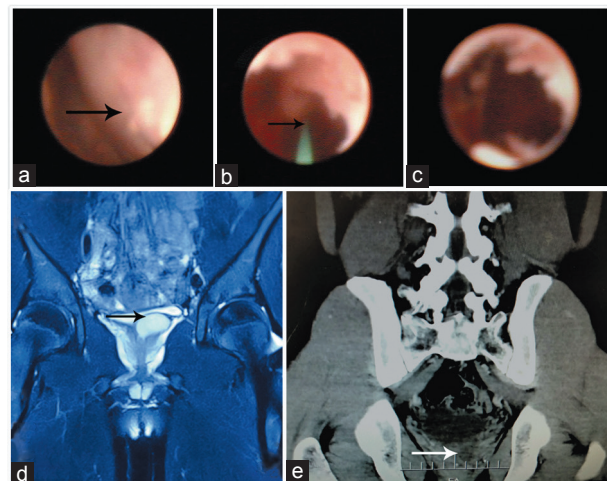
Surgical images and radiological data of fenestration under seminal vesiculoscopy. (a) The image of seminal vesiculoscopy and seminal cyst could be clearly identified by its bulging contour (arrow). (b) The process of fenestration by using holmium laser under seminal vesiculoscopy (arrow). (c) The final result of operation and most of the cyst wall was removed. (d) The preoperative MRI image of the seminal cyst (arrow). (e) Rechecking CT image took at 6 months after the surgery, and a recurrent cystic lesion could be found at the operating area (arrow). MRI: Magnetic resonance imaging; CT: Computed tomography.
